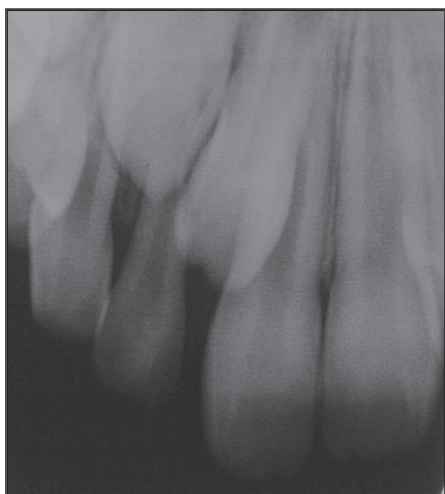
Case 2: A periapical radiograph taken at the age of 7 years, 10 months shows the 2 right lateral incisors which are similar in shape.
